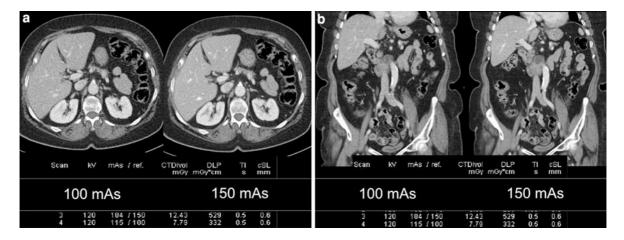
Comparison of two consecutive CT enhanced acquisitions of the abdomen with a dose reduction of 33% in an 88-year-old woman weighting 87 kg. The first is performed with 120 kV and 150 mAs effective, and the second with the same
